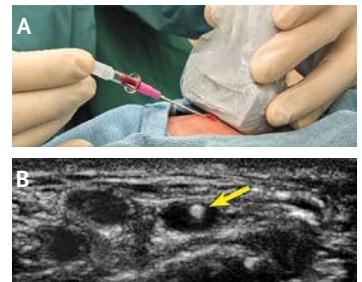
Ultrasound-Guided Catheterization in the Transverse Orientation.
